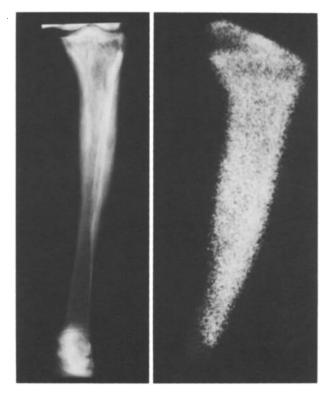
X-ray (A) and bone scan (B) showing Pagetoid involement of the left tibia
